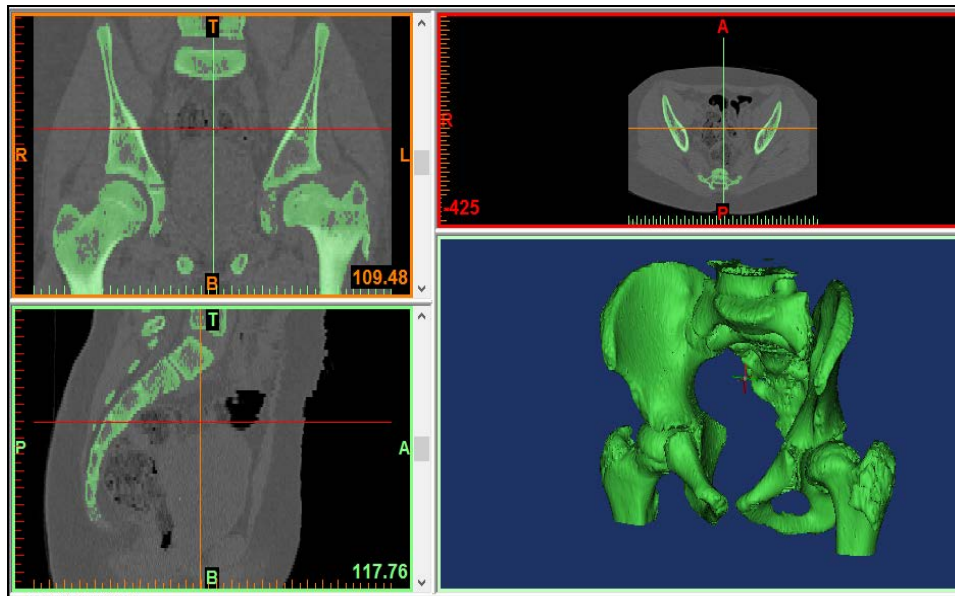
Biofidel medical Image from Computerized Tomography (CT) of a patient pelvis: Point clouds raw data
